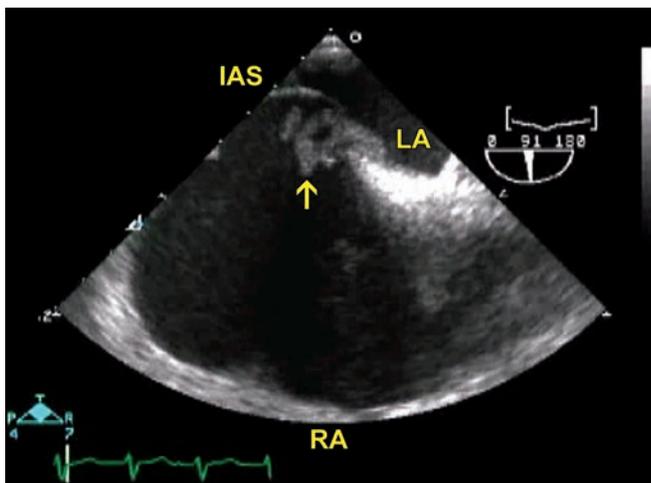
Transesophageal echocardiography: Arrow points to a large mass of thrombi, some with mobile components, wedged in the PFO.
